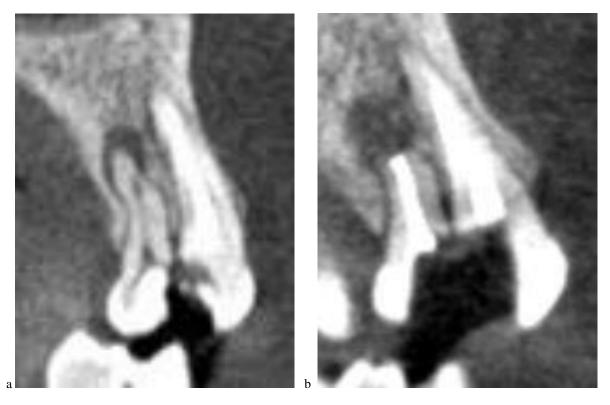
a) preoperative CBCT b) Post-operative CBCT
